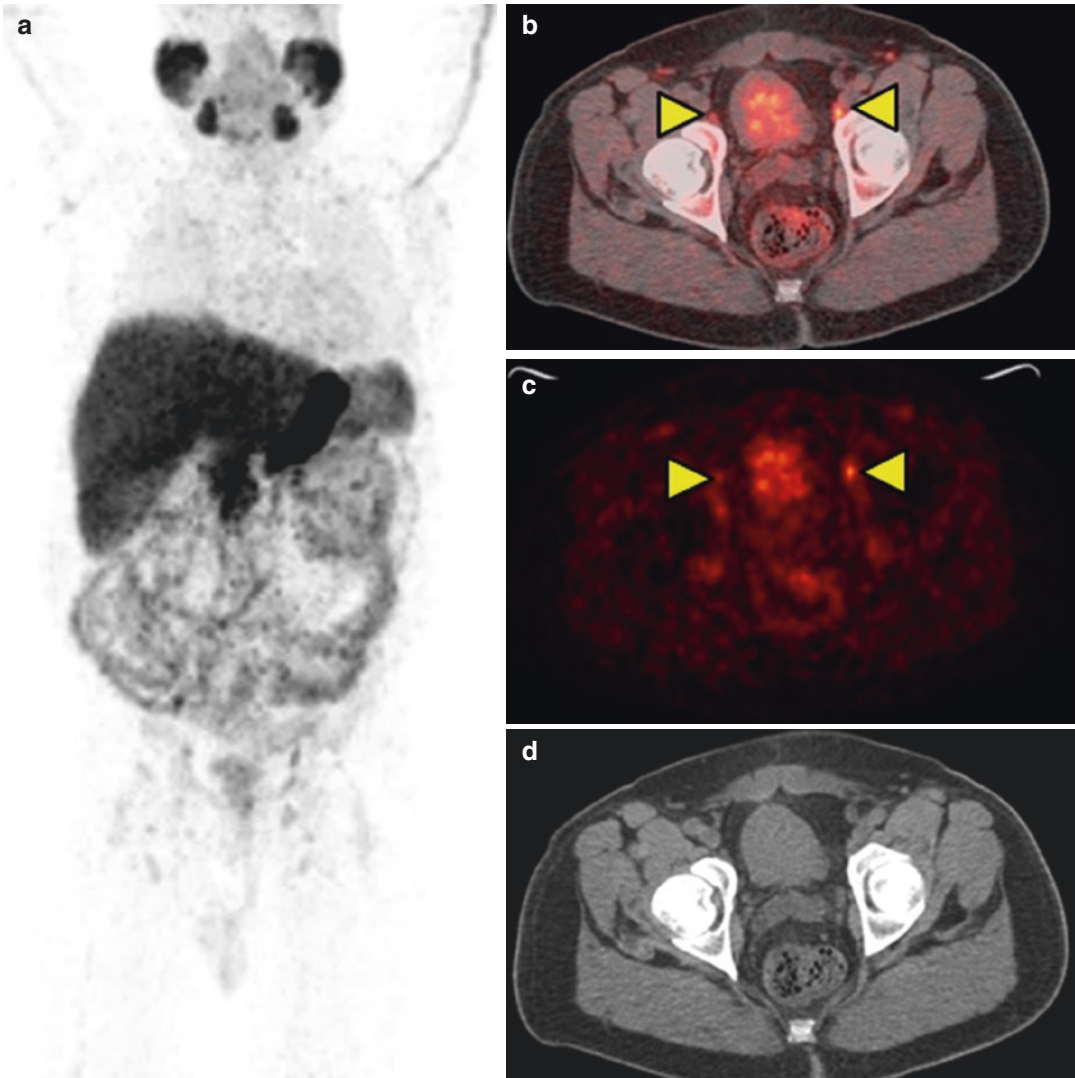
$[^{11}\text{C}]$ Acetate-PET/CT in a man with recently diagnosed prostate cancer involving the left lobe of the prostate. A whole-body maximum intensity projection (MIP) image (a) and fused PET/CT (b) and PET (c) images demonstrate increased activity in bilateral external
